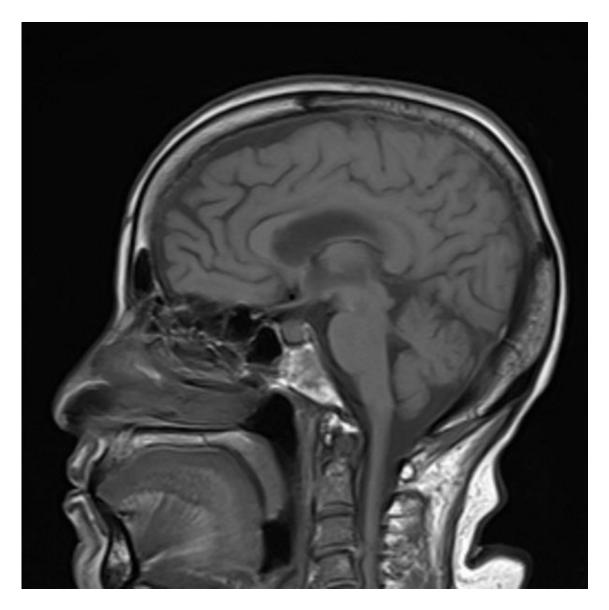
T1 SE (spin eco) sag MRI brain scan image.
